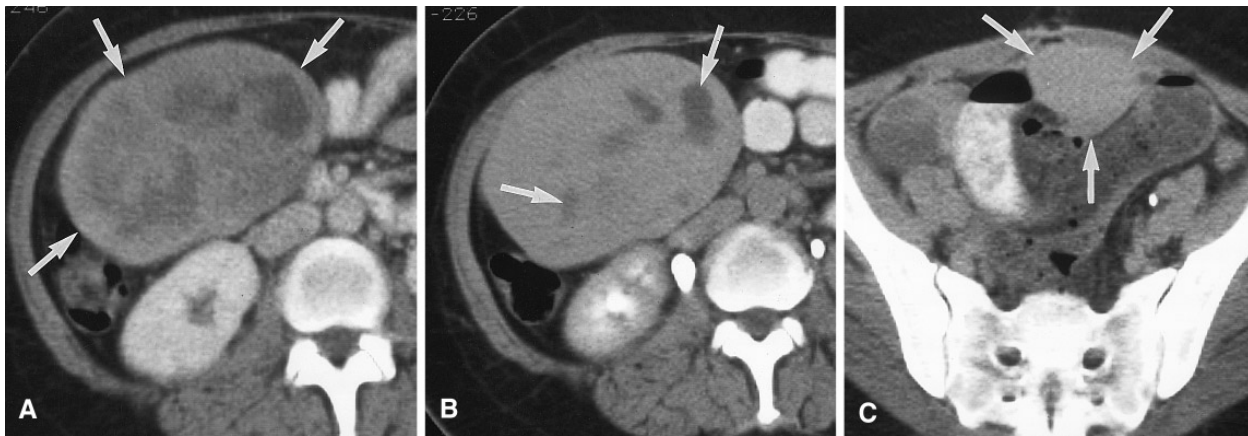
A Enhanced axial CT shows a heterogeneous soft tissue mass (arrows) in the right mid abdomen. B Delayed axial CT obtained at a level similar to A reveals that portions of the mass do not enhance
